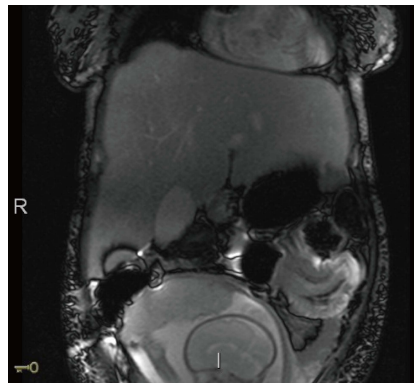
Magnetic resonance imaging of the abdomen showing an entero-enteric intussusception in the left upper quadrant.
